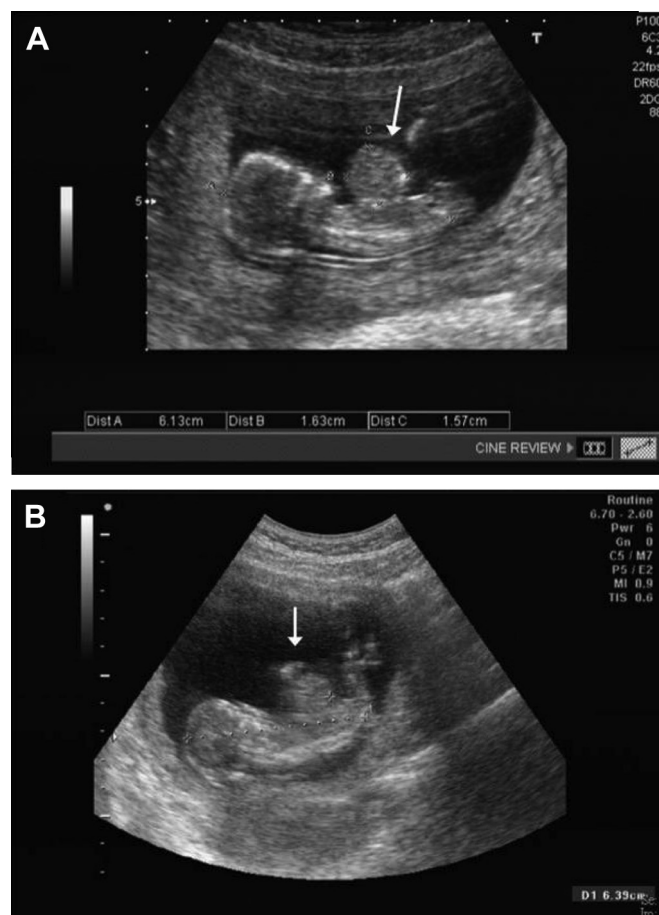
(A) Prenatal ultrasound at 12 weeks of gestation during the first pregnancy shows an isolated omphalocele (arrow); (B) prenatal ultrasound at 12 weeks of gestation during the second pregnancy shows an isolated omphalocele (arrow).
